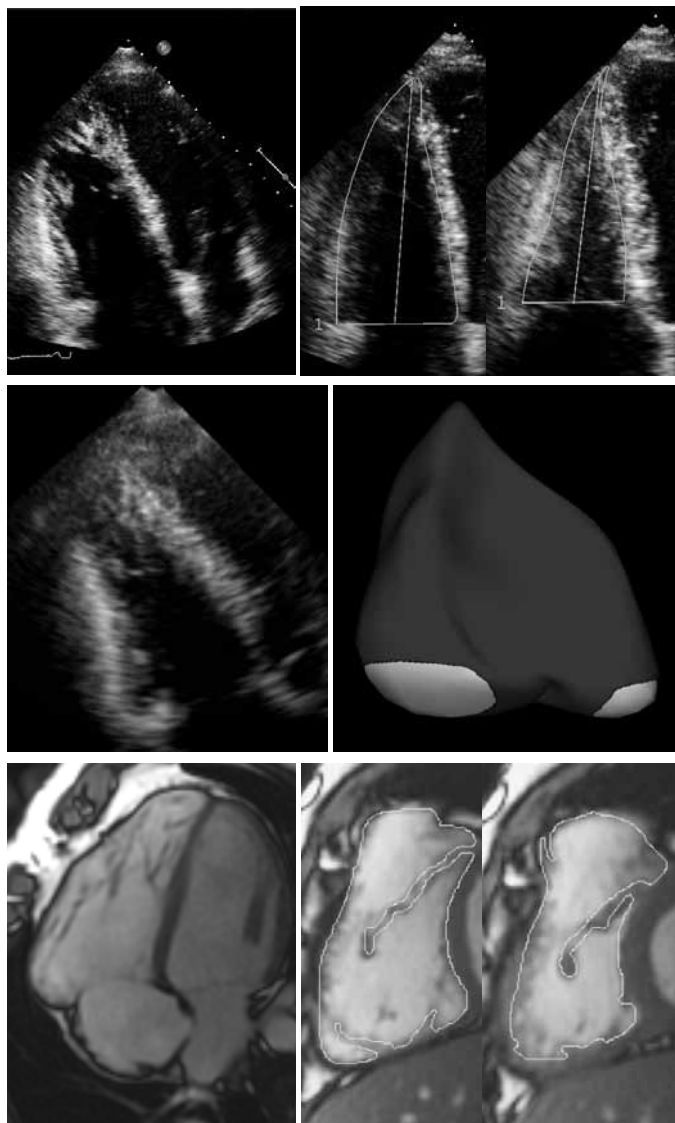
Example of radial long-axis images of the right ventricle obtained at end-diastole from a patient with pulmonary valve stenosis displayed by 2-dimensional echocardiography (top), 3-dimensional echocardiography (center) and cardiac magnetic resonance imaging (bottom) with their respective measurements.
